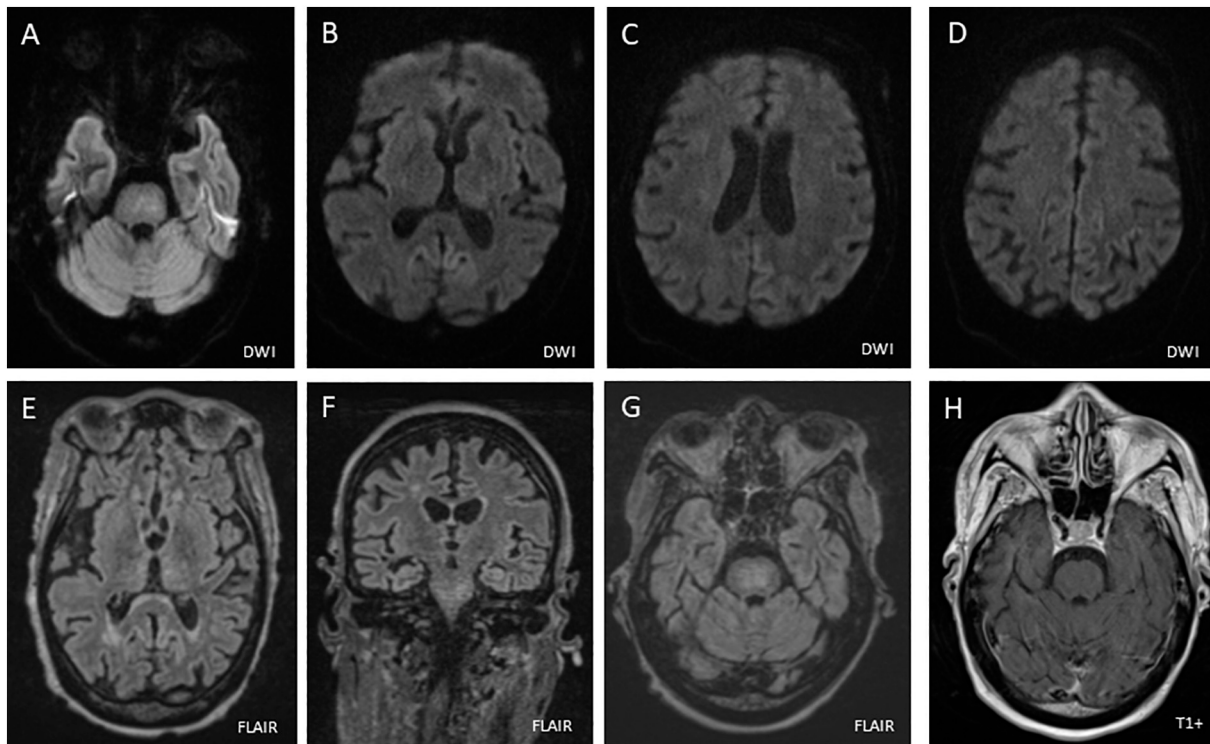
Different MRI sequences showing a near resolution of the previously demonstrated lesions in Fig. 1. This occurred in response to treatment with pulse steroid therapy and plasmapheresis as described in the case. These were accompanied by improvement in mental status.
